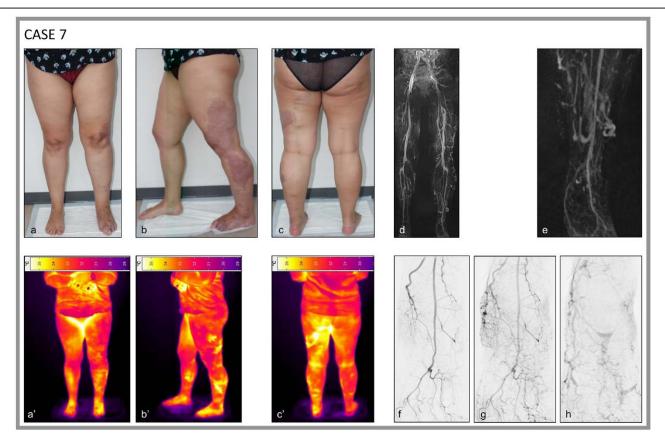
Patient with PIK3CA-PWS and referral diagnosis of KTS (case 7). Patient photos (A–C), corresponding thermographic images (A'–C'), MR images with time-resolved angiography with interleaved stochastic trajectories (TWIST) and golden-angle radial sparse parallel (GRASP) sampling sequences of both legs (D) and left calf and foot (E), as well as digital subtraction angiography (DSA) of the left calf and foot at an early (F), late (G), and very late phase (H). KWS indicates Klippel-Trenauny syndrome; PWS, Parkes Weber syndrome.
